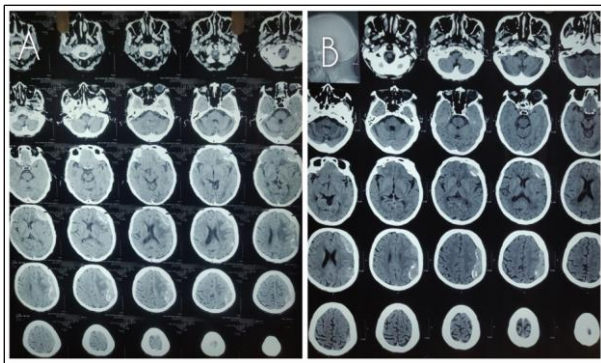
A & B: CT scan brain plain showing left sided frontoparietal calcified chronic subdural hematoma.
